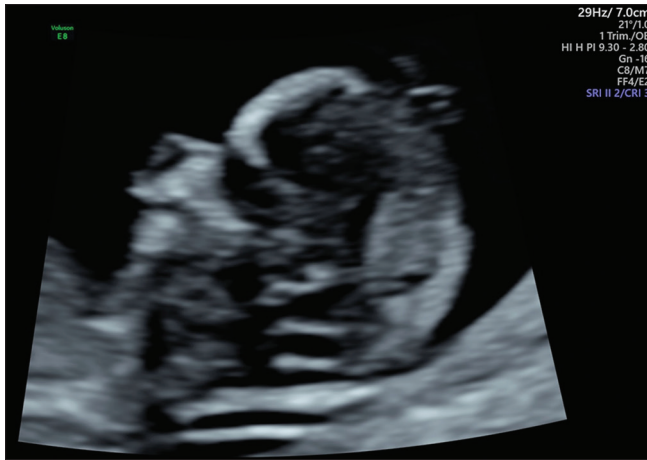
First-trimester ultrasound: parasagittal section of the fetal head with receding chin
